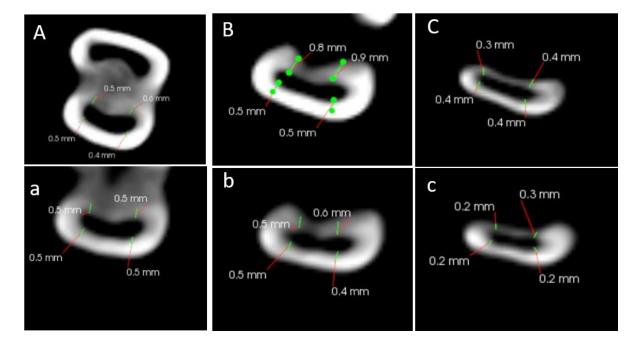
7 – Kedo S pre instrumentation CBCT images for dentin thickness at A.cervical level, B.middle level and C.apical level;
